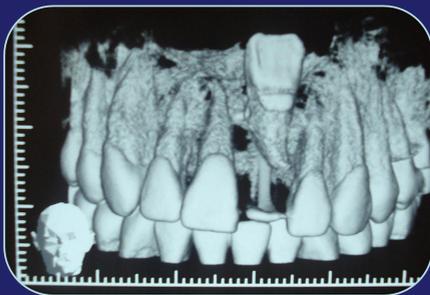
Initial Cone beam, 3D and axial views
